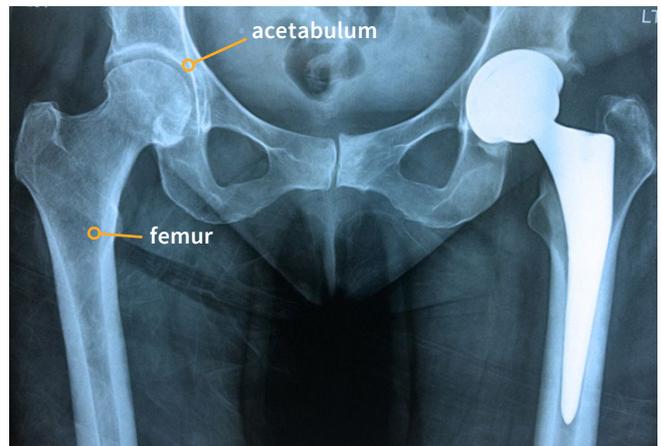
Plain x-ray of hips and pelvis post surgery: shows a hip joint prosthesis.
